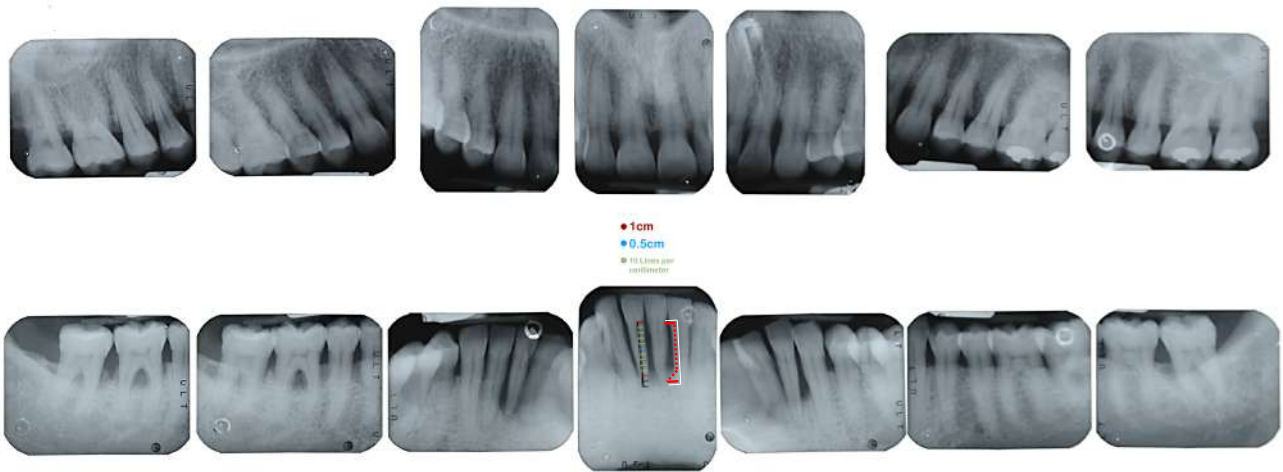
Estimation of radiographic bone loss at site that appears to have most severe destruction
